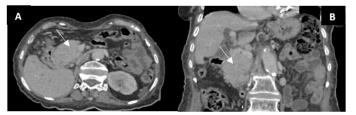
(A) Axial CT scan revealing a hypervascular mass in the pancreas; (B) Coronal CT section demonstrating the hypervascular mass in the pancreatic head.
